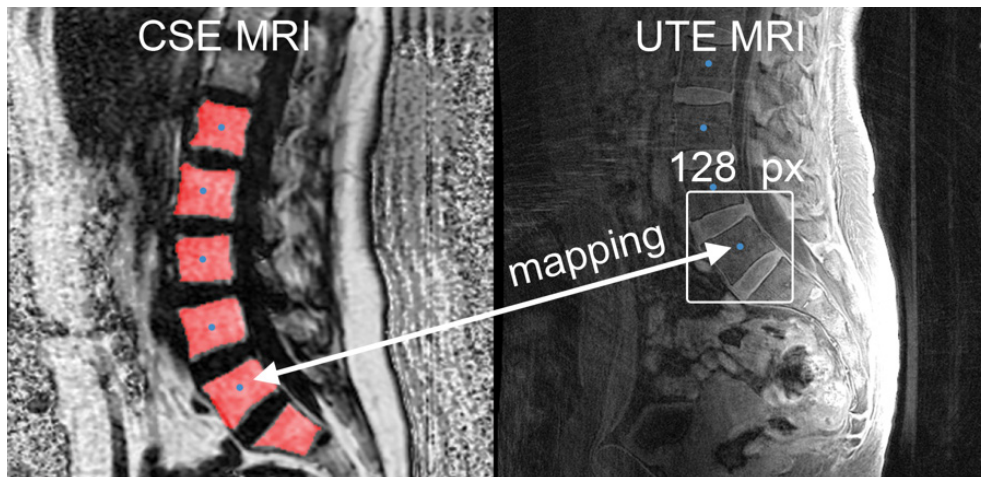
Lumbar vertebral segmentations (red) for the CSE images were used to identify the L5 vertebral body centroid in CSE and UTE space to facilitate automated image cropping. CSE, chemical-shift encoding based; UTE, ultra-short echo time; MRI, magnetic resonance imaging.
